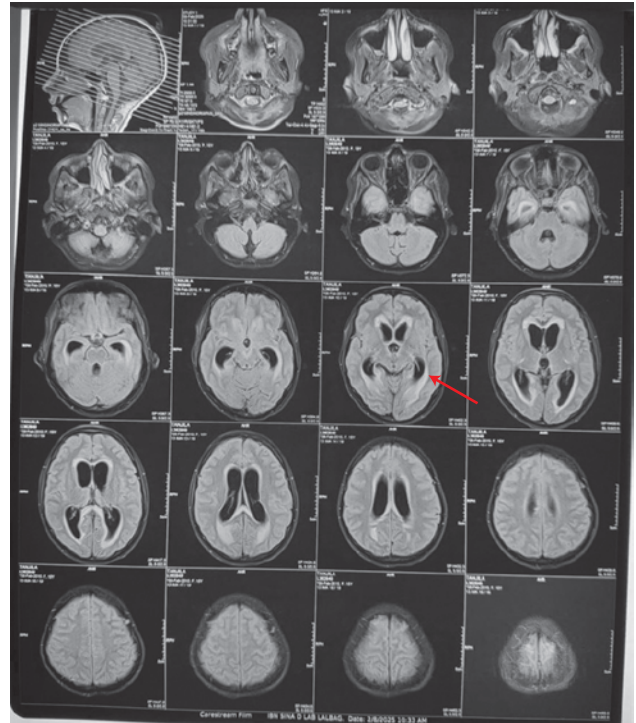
Periventricular diffuse T2-FLAIR hyperintensity (red arrow) in MRI Brain suggests chronic periventricular ischemic change.
